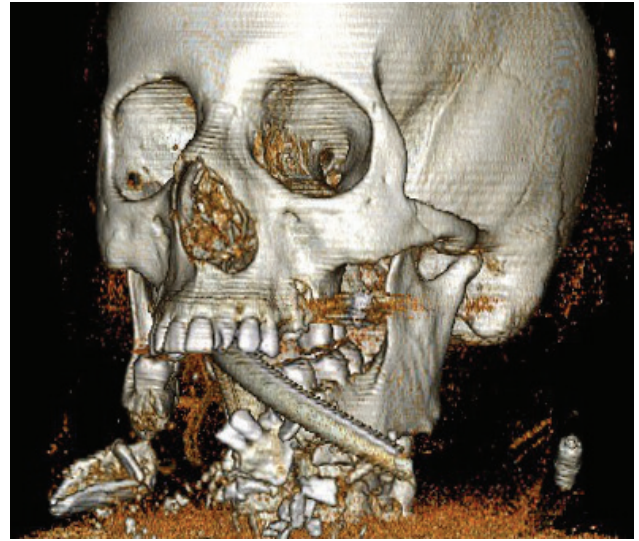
Three-dimensional reconstruction of CT (computed tomography) face showing avulsed mandibular symphysis.
